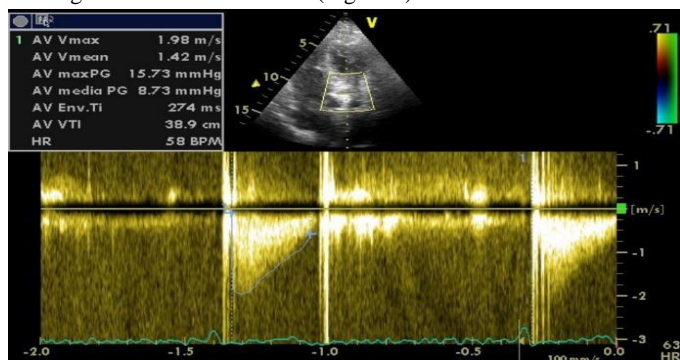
Echocardiography performed in 2014, before ESMR.
